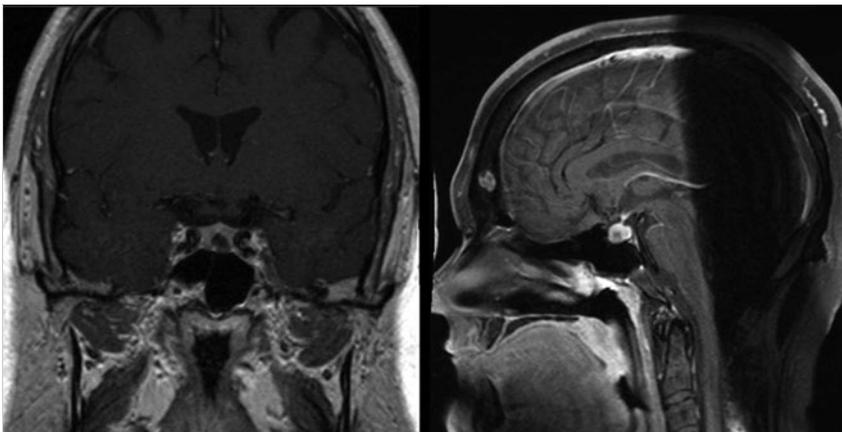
Corticotropinoma. Coronal and sagittal T1-weighted gadolinium-enhanced images revealing a left-sided intrasellar adenoma.
